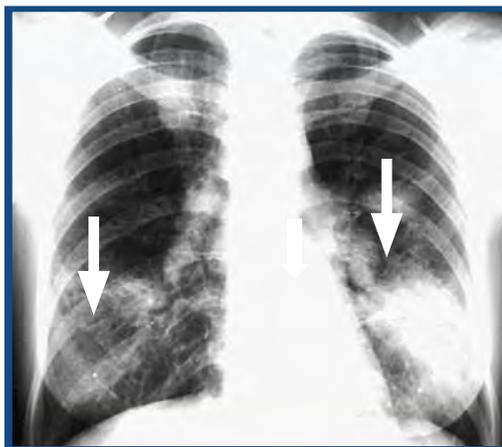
Chest radiograph of Stage III Sarcoidosis – involvement of lung tissue (arrows) without swollen lymph nodes
